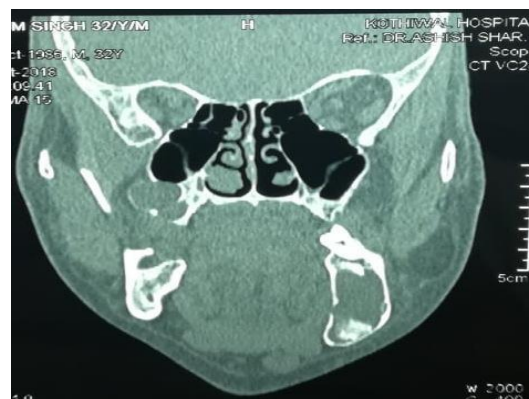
A coronal cone-beam computed tomography scan showing a multilocular, multicystic KCOT, with lingual perforation.
